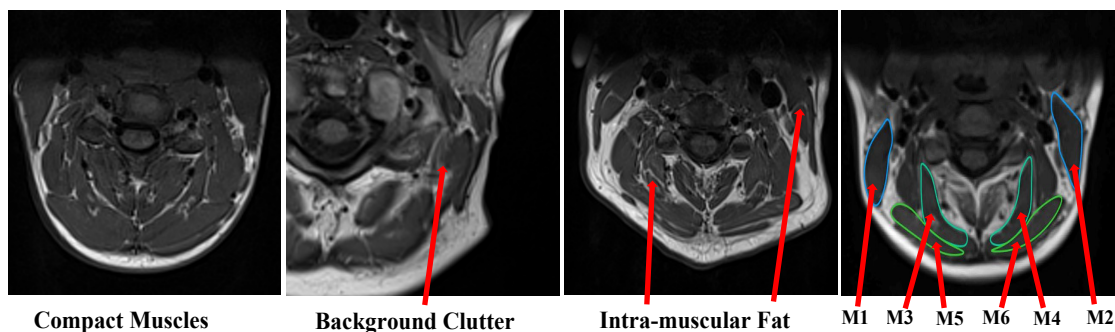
Challenges involved with neck muscles in MRI: compact and similar objects (left); background clutter (2nd from left); intra-muscular fat (3rd from left); and six neck muscles considered in this dissertation denoted as M1, M2, M3, M4, M5 and M6, respectively (right).
